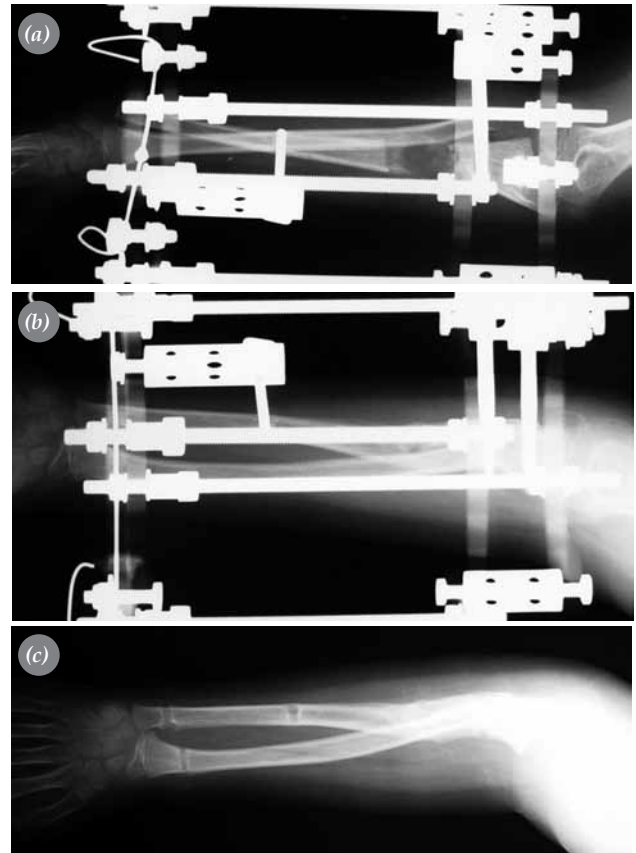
Radiographs of the patient with brachial plexus injury (a, b) at the end of the lengthening and (c) after removal of the external fixator.
